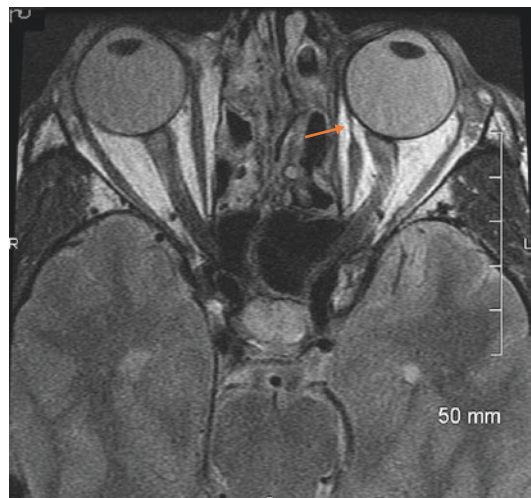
Orbital MRI of patient with a lost left medial rectus muscle secondary to a penetrating nasal orbital injury OD. Imaging suggests that the left medial rectus is still attached to the globe by a thin strip of connective tissue (*arrow*). In fact, at surgery no such connection was found. This is the *collapsed empty channel sign*
